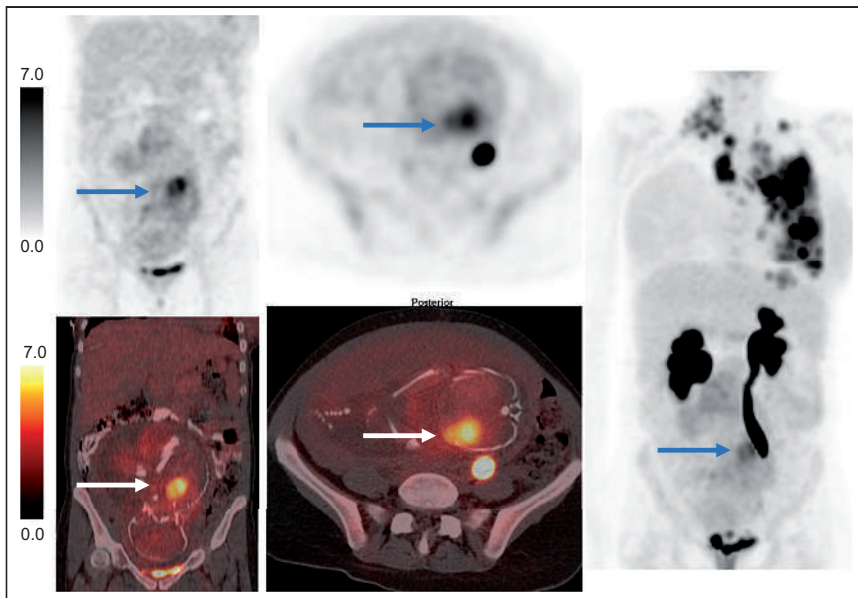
Example of concentrated uptake of  $^{18}\text{F}$ -FDG in fetal heart (arrows) for patient in second trimester at 28 wk (entering third trimester).
